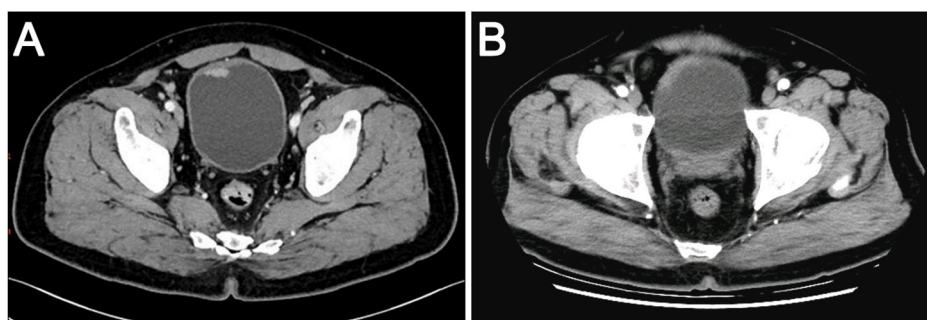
Computed tomograph (CT) scan shows the calcified right anterolateral mass lesion. A: First bladder malignancy (urothelial carcinoma); B: Second bladder malignancy (leiomyosarcoma).
